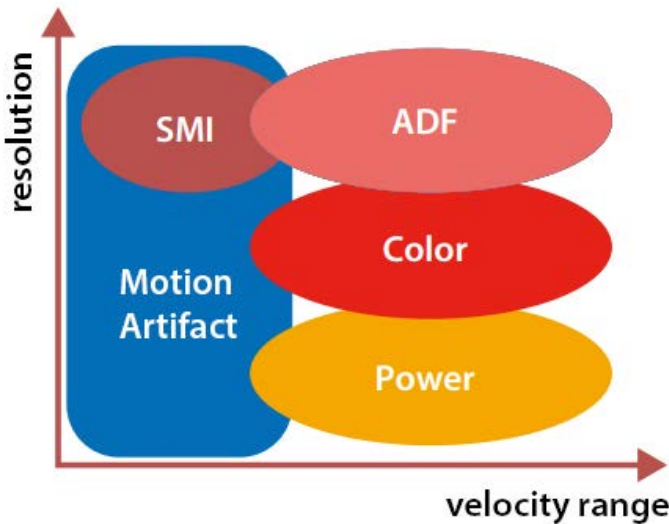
SMI features high resolution and better sensitivity to low-velocity blood flow than existing Doppler technologies.
